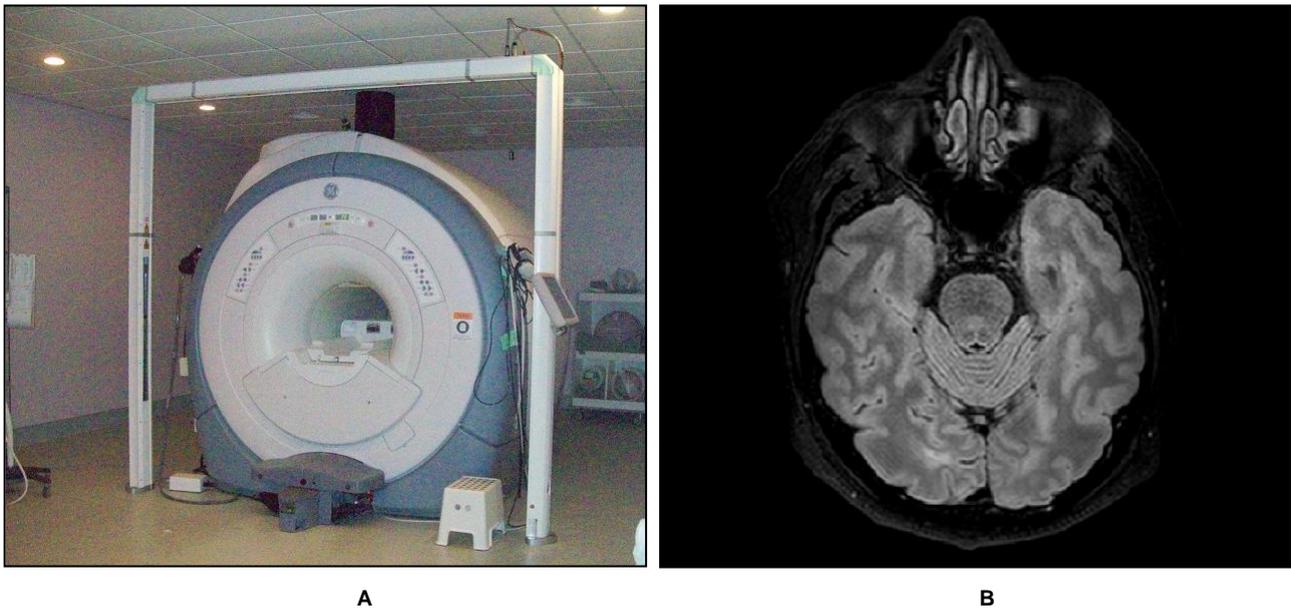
A: MR scanner (*GE Signa® HDxt 3.0T* scanner). B: Axial brain MRI.
